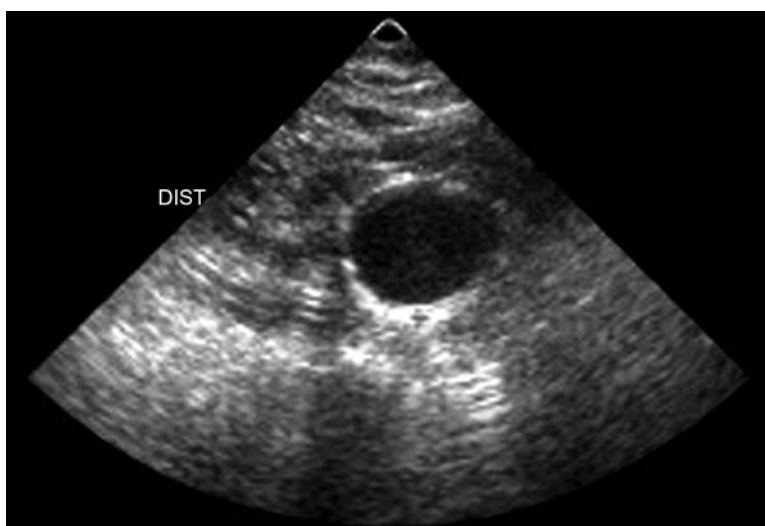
A bedside ultrasound of an enlarged abdominal aorta
